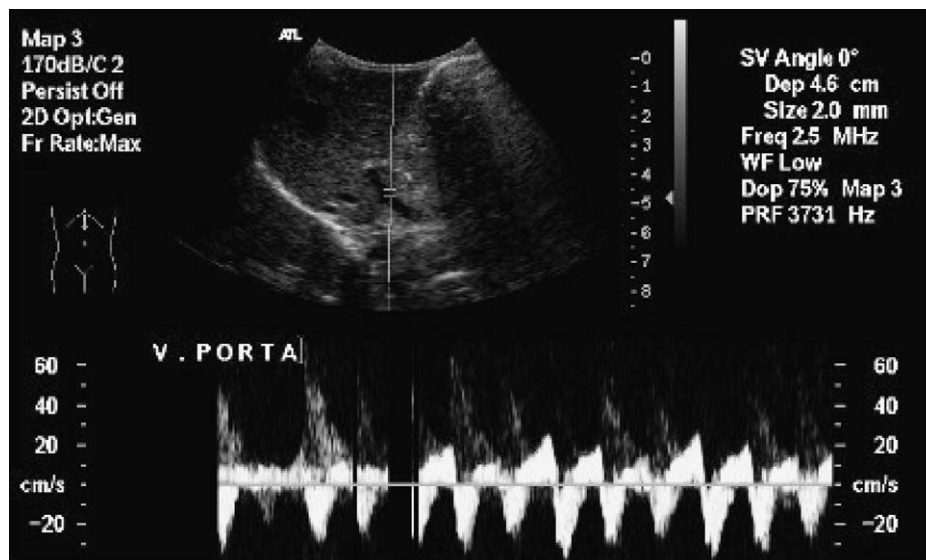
Ultrasound of the abdomen in the midline. The doppler is positioned in the proximal part of the splenic vein. The spectrum shows an arterial signal.
